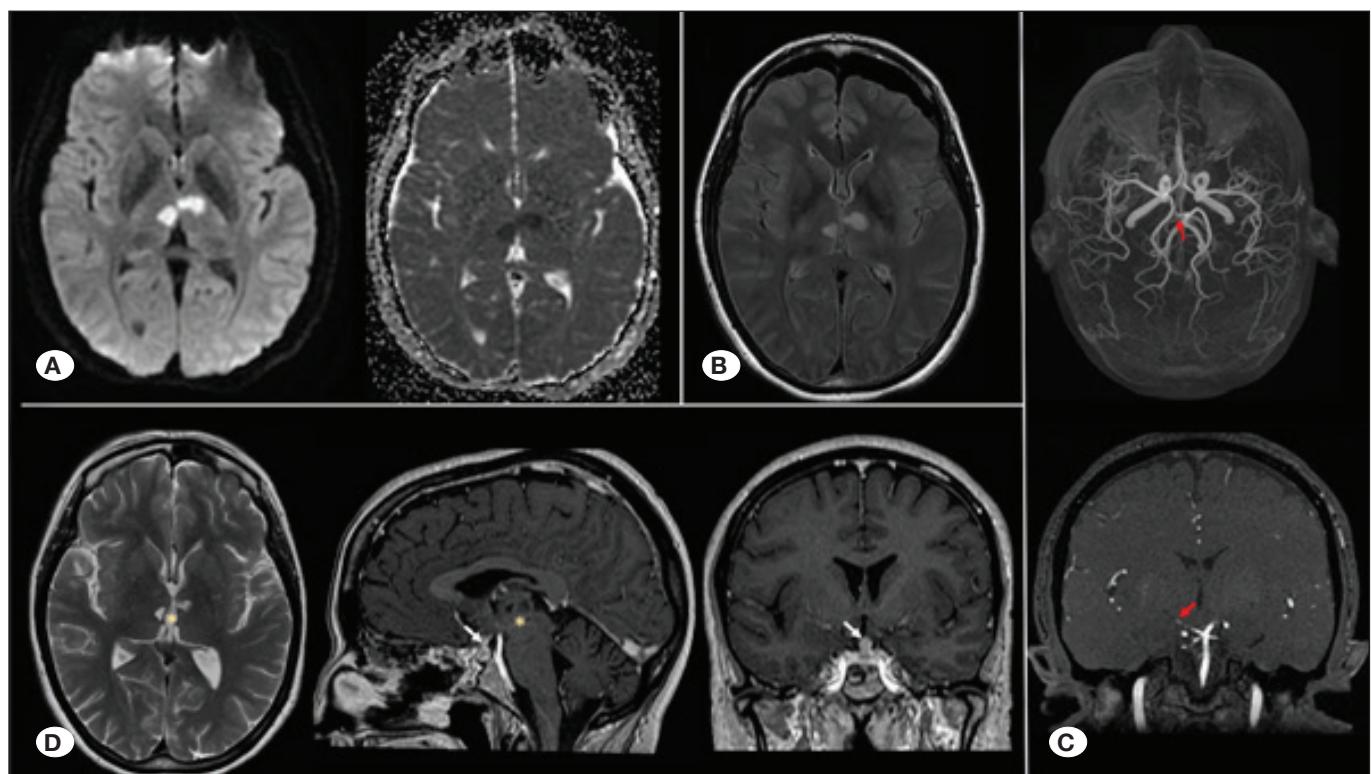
Early postoperative MRI shows bi-thalamic restrictive signal (A) on DWI sequence (diffusion-weighted), ADC (apparent diffusion coefficient), and hyperintensity on T2/FLAIR correlating with bi-thalamic ischemia (B). MRA shows fetal variant of right PCA and Percheron artery origin at P1 segment of the right PCA, with evidence of caliber reduction and distal signal attenuation (red arrow) (C). Postop MRI at three months (D) showing bi-thalamic increased T2 and decreased T1 signal (yellow asterisk), as well as persistence of pituitary stalk thickening (white arrow).
